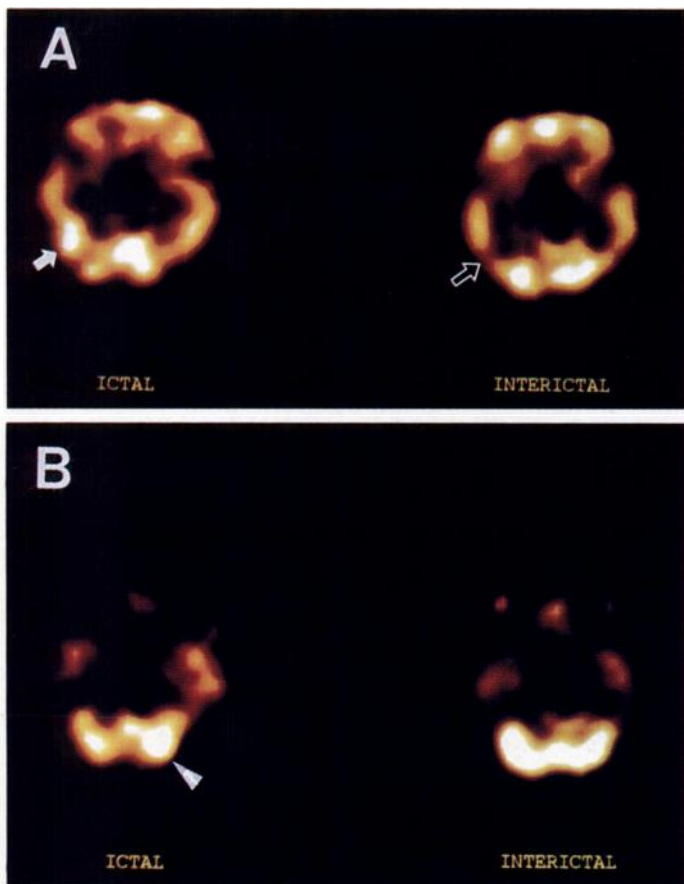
Right occipital lobe epilepsy in a 17-yr-old boy. (A) On ictal SPECT, there is subtle increased tracer uptake at the right occipital lobe (arrow). Interictal SPECT shows a focal area of decreased perfusion at the same site of the occipital lobe (open arrow). (B) Increased uptake of contralateral cerebellum (arrowhead) is more obvious than that of the occipital epileptic focus. Confirmation was made by ECoG with grid insertion. Interictal scan shows equalized cerebellar activity.
